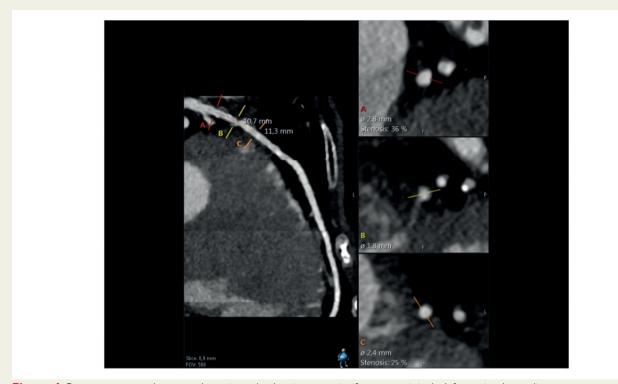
Coronary computed tomography angiography showing a non-significant stenosis in the left anterior descending artery.
